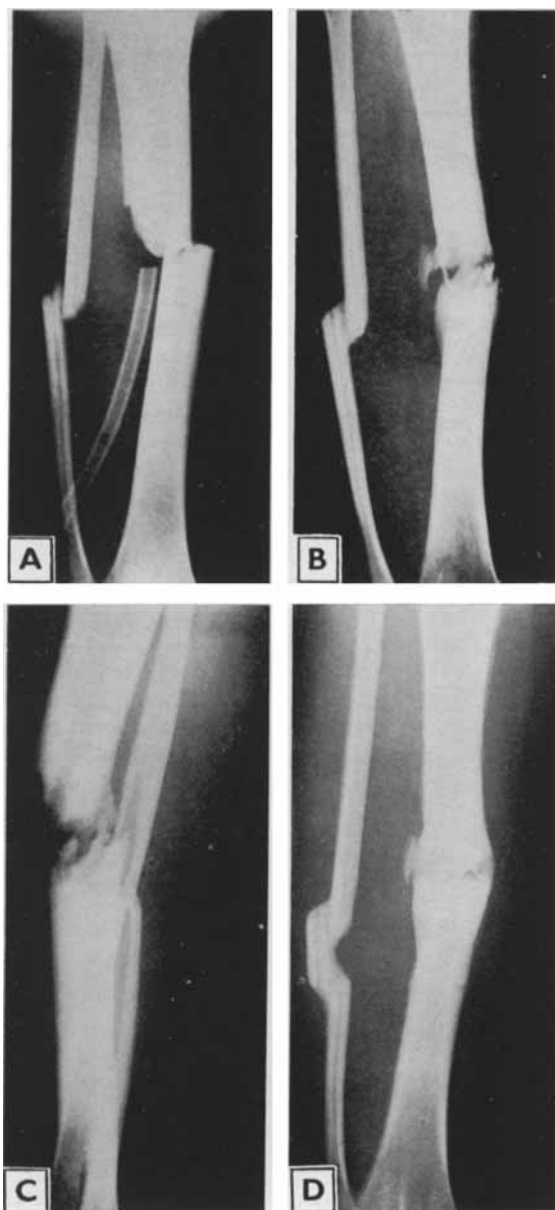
Case No. 40.* — Roentgenograms of a case with serious compound fracture of tibia and fibula with bone defect of the tibia (A). The case was complicated by osteitis and non-union (B, C). Surgical treatment was osteotomy of fibula and compression-osteosynthesis of tibia. Combined growth hormone and thyrotropin treatment was applied during eight weeks, plus antibiotics. — The symptoms of inflammation were allayed and solid osseous union was achieved in 8 months (D). — Cf. Fig. 8.
